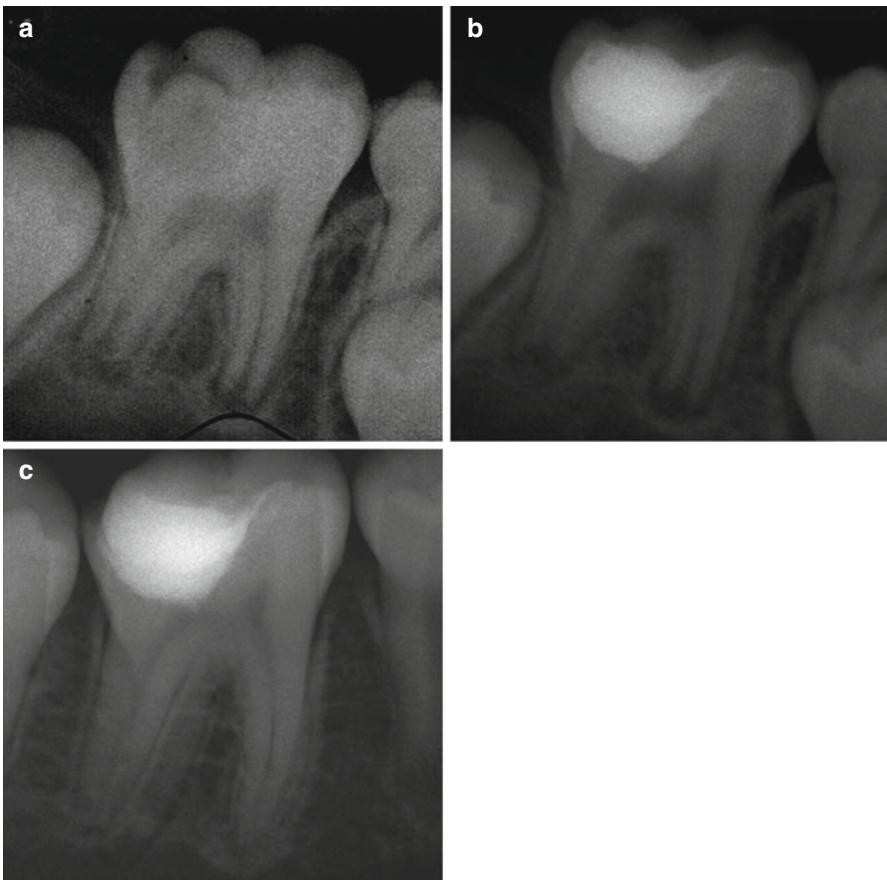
(a) Preoperative radiograph of a 7-year old child, showing first mandibular molar with deep caries. (b) After excavation and carious exposure and MTA application. (c) Postoperative 3-year follow-up. Tooth vitality present and completed root formation (Courtesy of Dr. G. Bogen)
